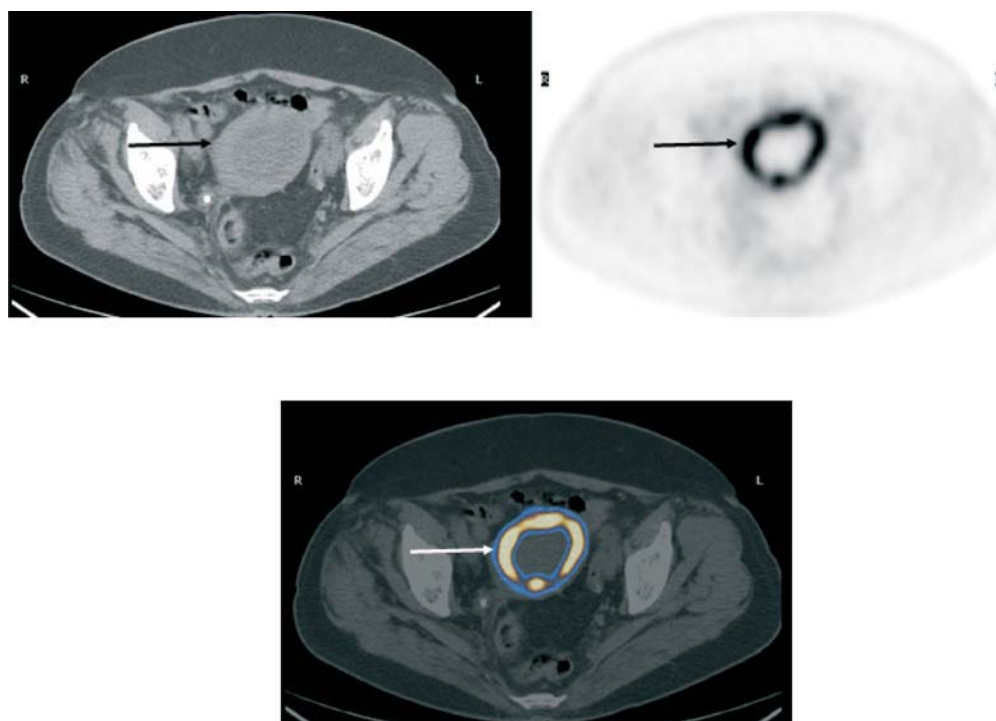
A 61-year-old woman with stage IV endometrial cancer had completed chemotherapy and radiotherapy and was being considered for surgery. PET/CT imaging was performed to exclude metastatic disease. There was no evidence of disease outside the uterus. The transaxial images of CT (*top left*), PET (*top right*), and PET/CT fusion image (*lower*) showed persistent FDG uptake in the primary endometrial tumor indicating residual tumor.
